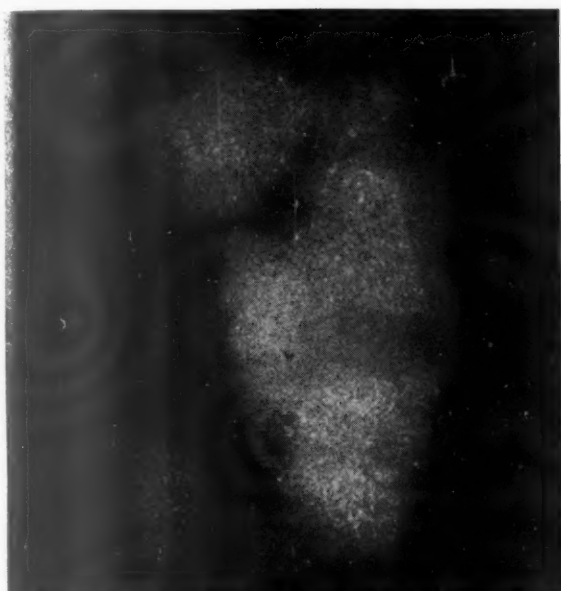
Case 1. Post mortem radiograph of kidney showing deposits in the pyramids.
